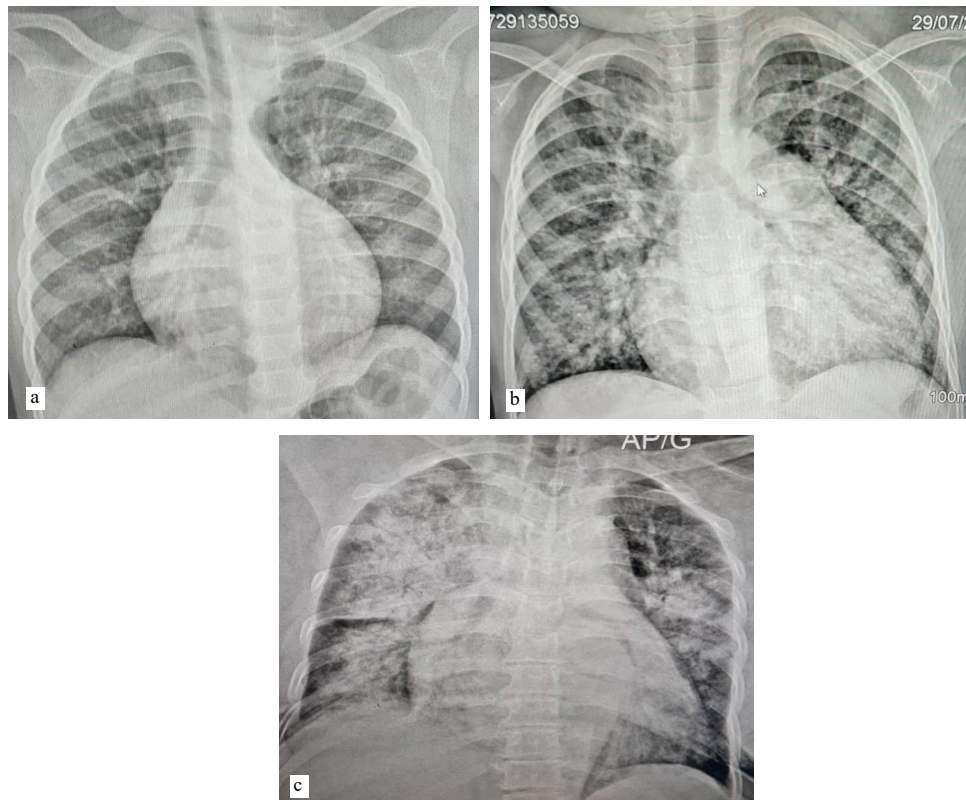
Frontal chest x-ray showing: (a) cardiomegaly (ICT=0.6) associated with vascular redistribution towards the apices: cardiomyopathy; (b) cardiomegaly (ICT=0.7) with interstitial edema: Decompensated heart failure; (C) bilateral perihilar alveolar filling, asymmetrical butterfly wing in favor of PAO associated with cardiomegaly (ICT = 0.7).
